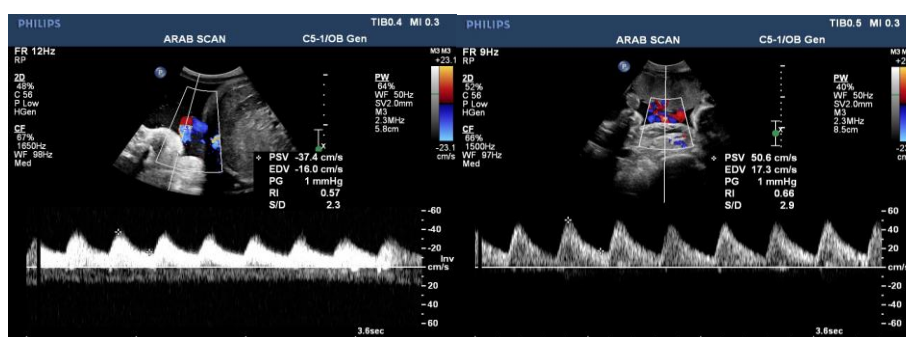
Showing a free floating loop of the umbilical cord and subsequently Doppler indices are obtained including RI and S/D ratio
